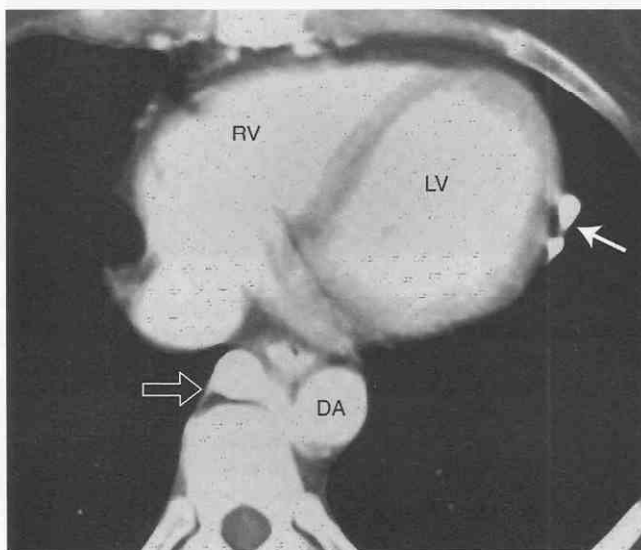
Enlarged pericardiophrenic vein. Axial CT with intravenous contrast medium shows marked distention of the pericardiophrenic vein (arrow), which is acting as a collateral in this patient with SVC obstruction secondary to fibrosing mediastinitis. The distended azygos vein (open arrow) is also providing collateral circulation. DA, descending aorta; LV, left ventricle; RV, right ventricle.
